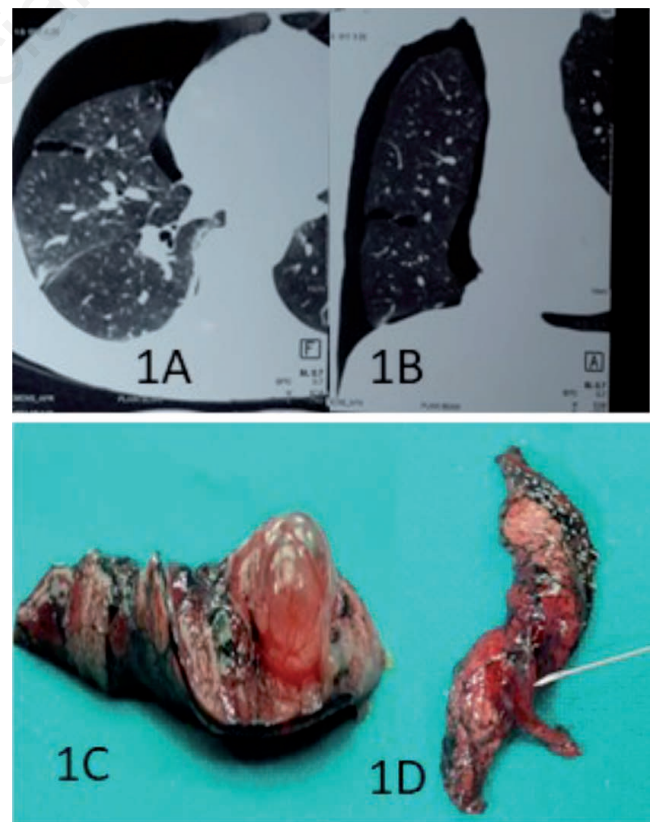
A) Non-contrast CT chest revealing right sided pneumothorax due to a ruptured bulla. B) A coronal view of the pneumothorax showing a ruptured and an intact bulla in the right lung. C) Wedge resection of the intact bulla. D) Wedge resection of the ruptured bulla marked by the pointer.
